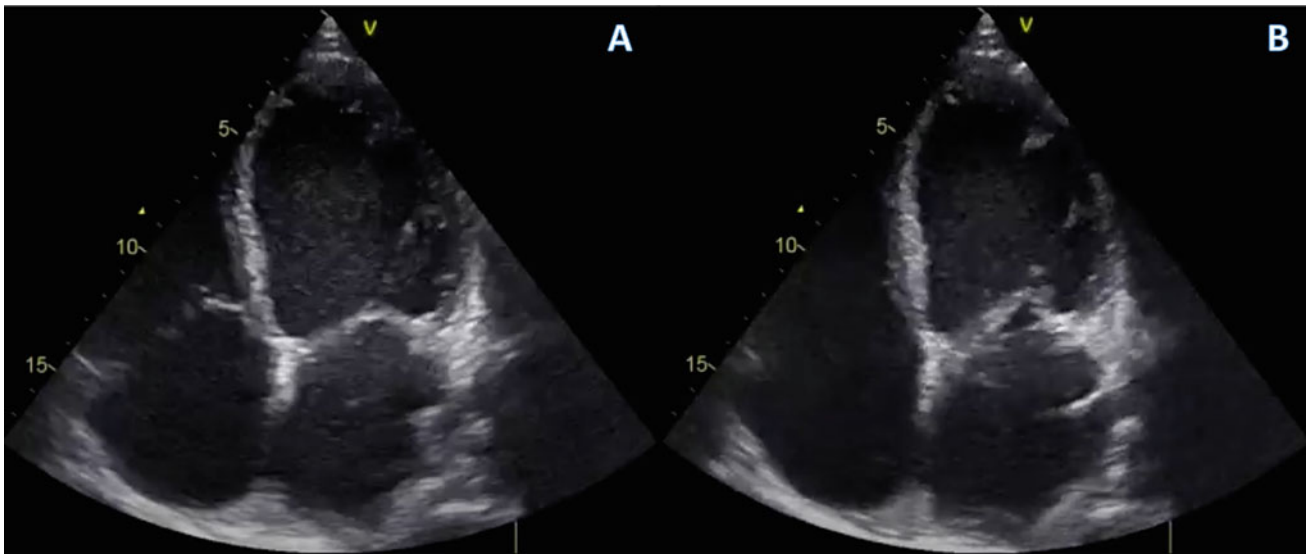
End diastolic and end systolic frames of trans-thoracic 2D echocardiography. Main findings: severe left ventricular dilation, bi-ventricular dilation, severe systolic dysfunction (LVEF 20%, Tricuspid Annular Plane Systolic Excursion [TAPSE] 10 mm, Right
